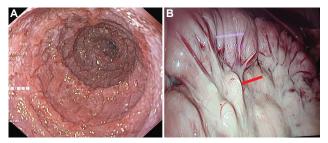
Contrast-enhanced computed tomography scan of abdomen Fig. 2. (A) Upper gastrointestinal endoscopic picture showing severe duodenal fissuring. (B) Laparoscopic picture showing ileal loops with enlarged mesenteric lymph nodes (red arrow).
